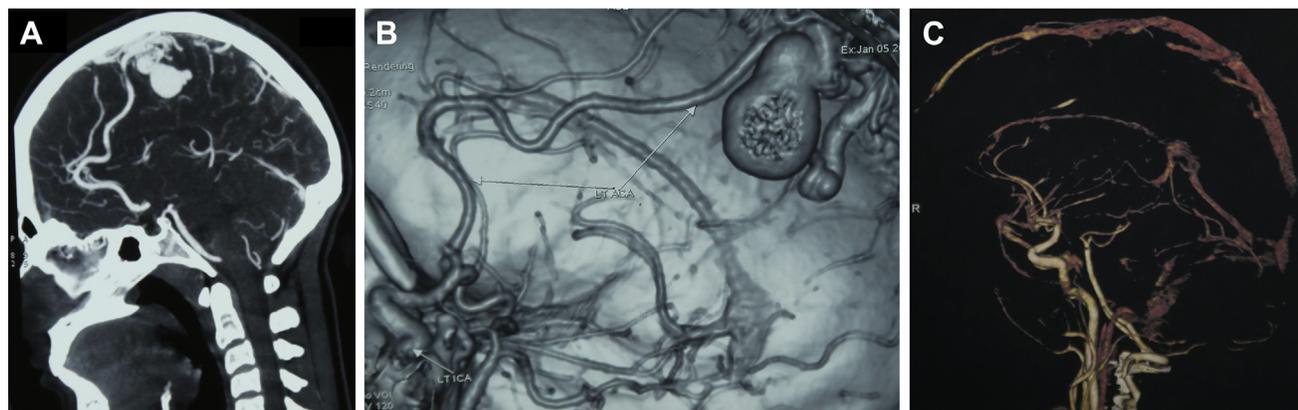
Images of an 18-year-old woman (case 2). (A) Sagittal image of computed tomographic (CT) angiogram showing a pial arteriovenous fistula (PAVF) fed by the anterior cerebral artery and draining into the superior
